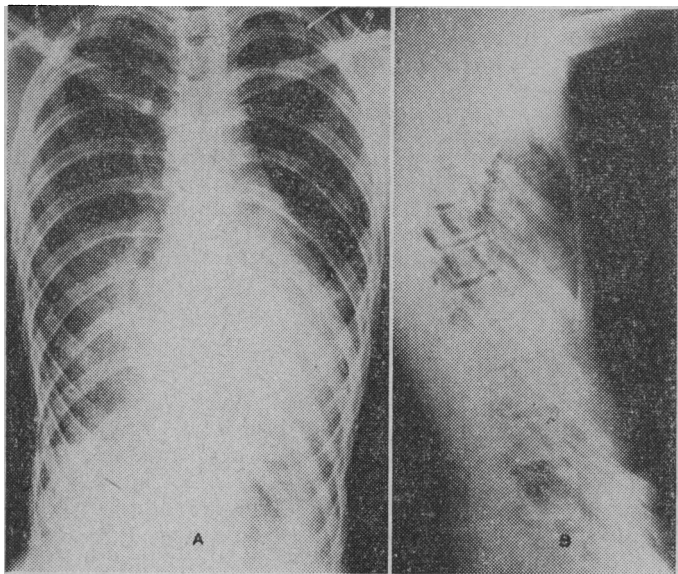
Posteroanterior and lateral chest radiographs showing severe sternal depression due to chest bandages. The bandages are in place.
